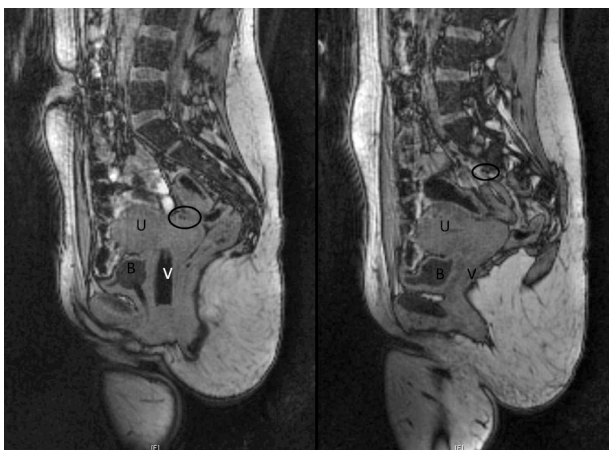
MRI images of the MESH fixation points on the cervix (fig. 1a) and promontorium (fig. 1b) with regard to the location of the bladder (b), uterus (u) and vagina (v).
